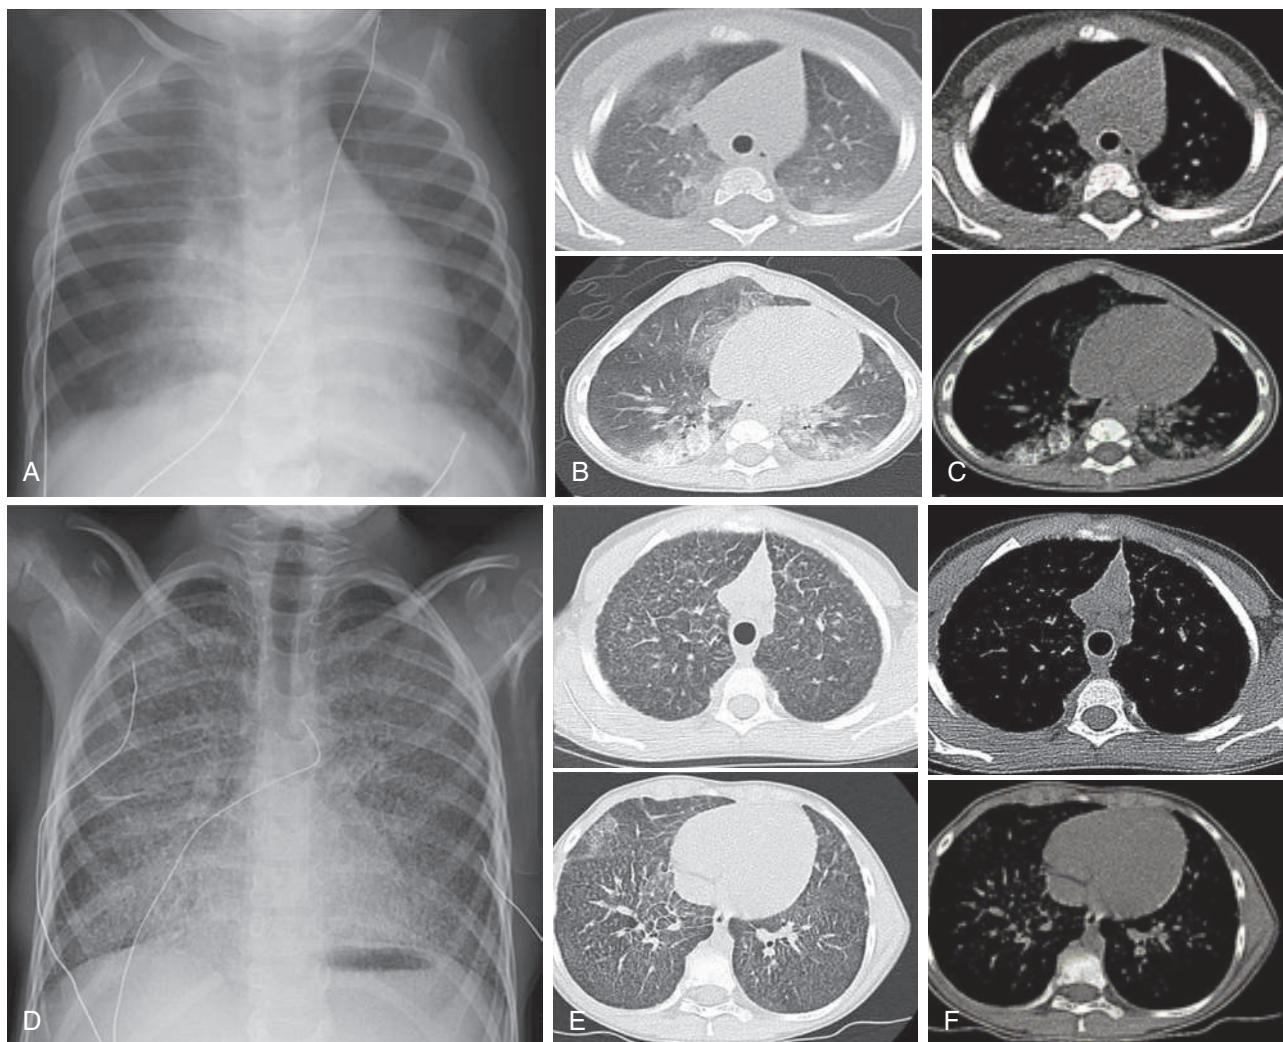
Pulmonary alveolar microlithiasis. Chest radiograph and high-resolution CT performed at the age of 1 year and 8 years. A, Chest radiograph shows bilateral alveolo-interstitial opacities with middle lobe consolidation. Chest CT imaging shows diffuse but patchy ground-glass opacities, alveolar consolidations in the middle and lower lobes, and calcifications in the lower lobes, at parenchymal (B) and mediastinal (C) windows. D, Chest radiograph shows diffuse, even predominant in the lower and middle lobes, dense reticulonodular opacities. Chest CT imaging shows patchy ground-glass opacities, homogenous miliary consolidations with micronodular calcifications and subpleural and interlobular reticulations, parenchymal retractions, and architectural distortion suggestive of fibrosis onset mostly in the upper lobes, at parenchymal (E) and mediastinal (F) windows. (From Sigur E, Roditis L, Labouret G, et al. Pulmonary alveolar microlithiasis in children less than 5 years of age. *J Pediatr.* 2020;217:158–164.e1, Fig. 1.)
